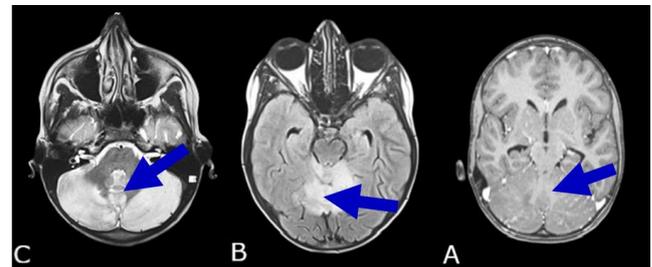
Magnetic resonance imaging (MRI) axial cut. Patient 2. (A) T1 injected, (B) T2 FLAIR Sequence, (C) T2 Sequence. Bilateral and asymmetrical diffuse cerebellar cortical thickening without systematized character, in discrete T1 hypo signal, T2 hypersignal and FLAIR, with discrete meningeal contrast taking in front of it, a mass effect on the brainstem and V4 without upstream dilation and ptosis of the cerebellar tonsils at the level of the Mc Rae line.
